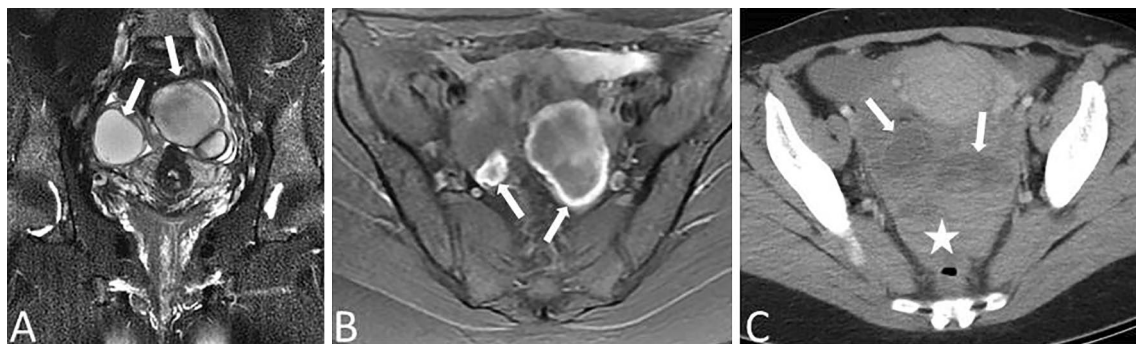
34-year-old female patient with previously known endometriomas. A and B Coronal fat-saturated T2W and axial fat-saturated T1W MR images show bilateral ovarian lesions (arrows) consistent with endometriomas. C The patient presented with acute onset pelvic pain three months after the first MRI examination. Axial postcontrast
